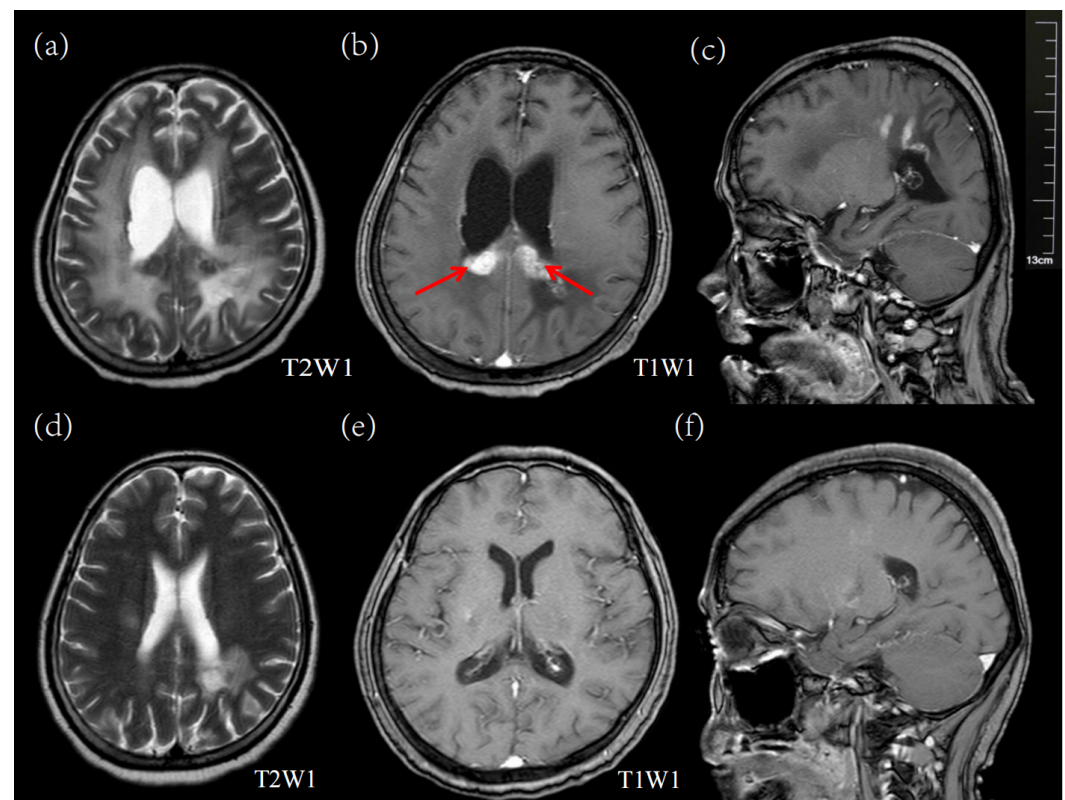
Pre- and post-treatment brain MRI scans of a patient with chemotherapy after surgery. (a–c) Pre-treatment images: Axial T2WI (a) and axial/sagittal T1WI enhanced images (b,c) show irregular long T2 signals with significant enhancement of the tumour shadow adjacent to the posterior horns of the bilateral ventricles. (d–f) Post-surgical and chemotherapy images: Axial T2WI (d) and axial/sagittal T1WI enhanced images (e,f) show that most of the lesions adjacent to the posterior horns of the bilateral ventricles disappeared after four cycles of chemotherapy. Red arrows indicate areas of abnormal signal intensity, suggesting lesion regions.
